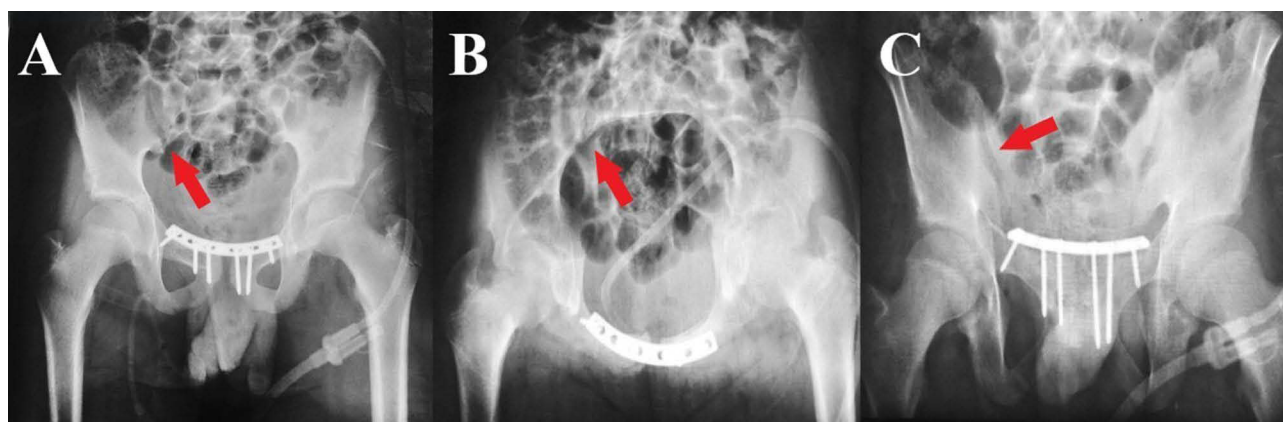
Immediate postoperative radiographs (A) anteroposterior. (B) inlet. (C) outlet views show symphysis pubis reduction, correct plate placement, and screws length; however, it was noted that the sacroiliac joint on the right side was disrupted (indicated by red arrowheads).
